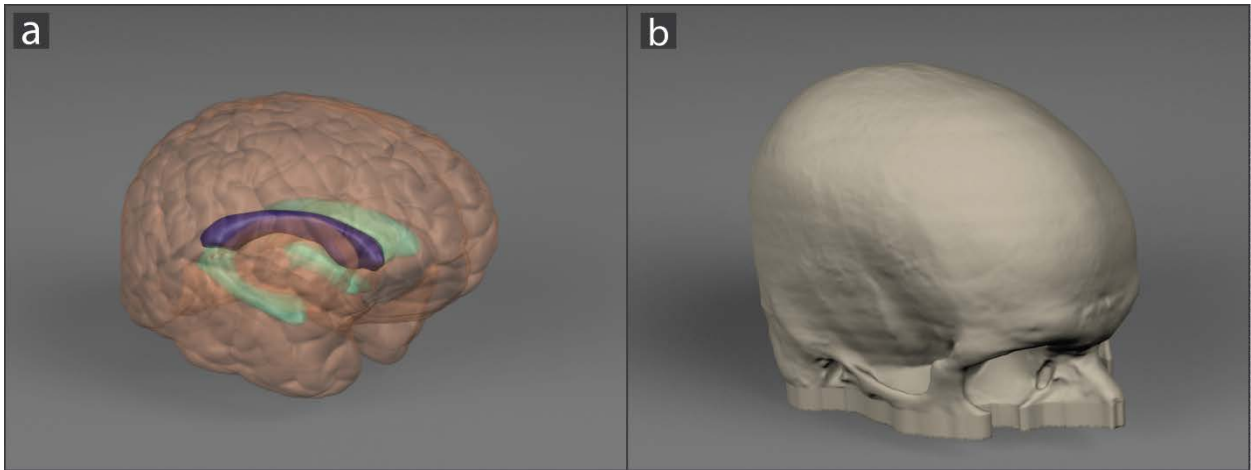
a) Rendering of the brain following MRI reconstruction. The lateral ventricles are highlighted in light blue. The anterior horn of the lateral ventricle rendered in dark blue is used in the final physical model. b) The skull has been truncated to increase durability of the model in addition to cost savings.
